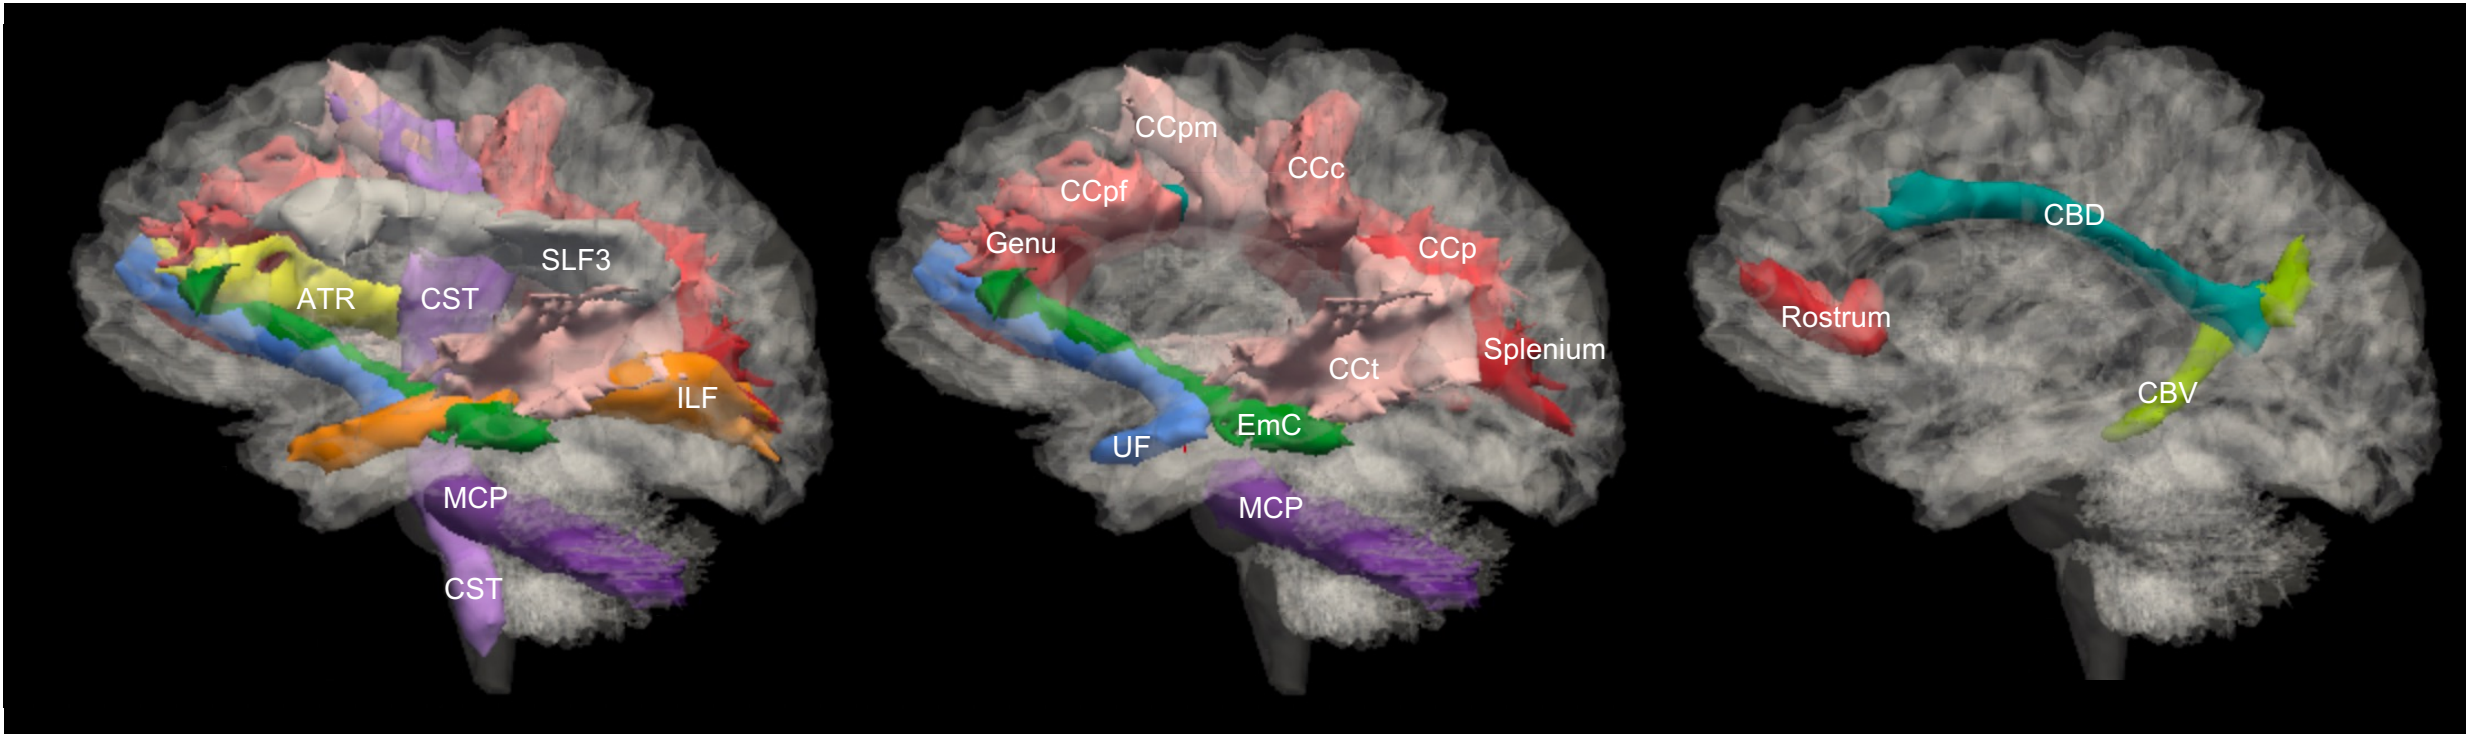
White Matter Regions for Diffusion MRI Analysis.
